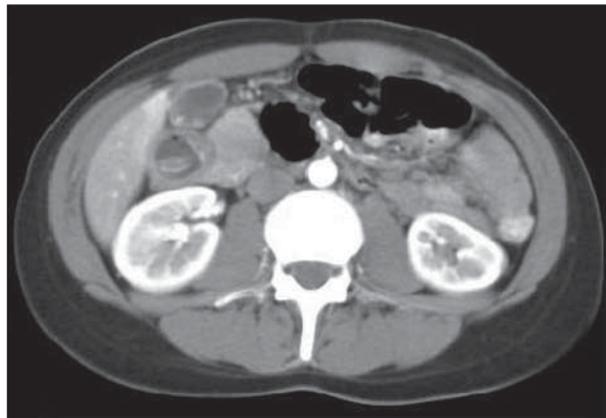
Abdominal computed tomographic scan showing cholelithiasis and a cystic mass adjacent to the second portion of the duodenum containing stones.
